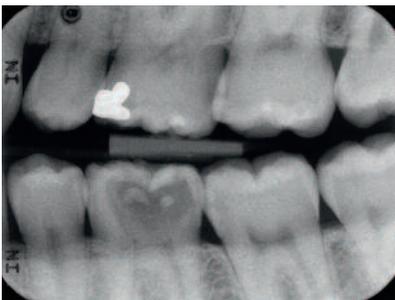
Bitewing Radiograph revealed signs of a deep carious lesion occlusal on tooth 36 of a 23-years-old male patient.
